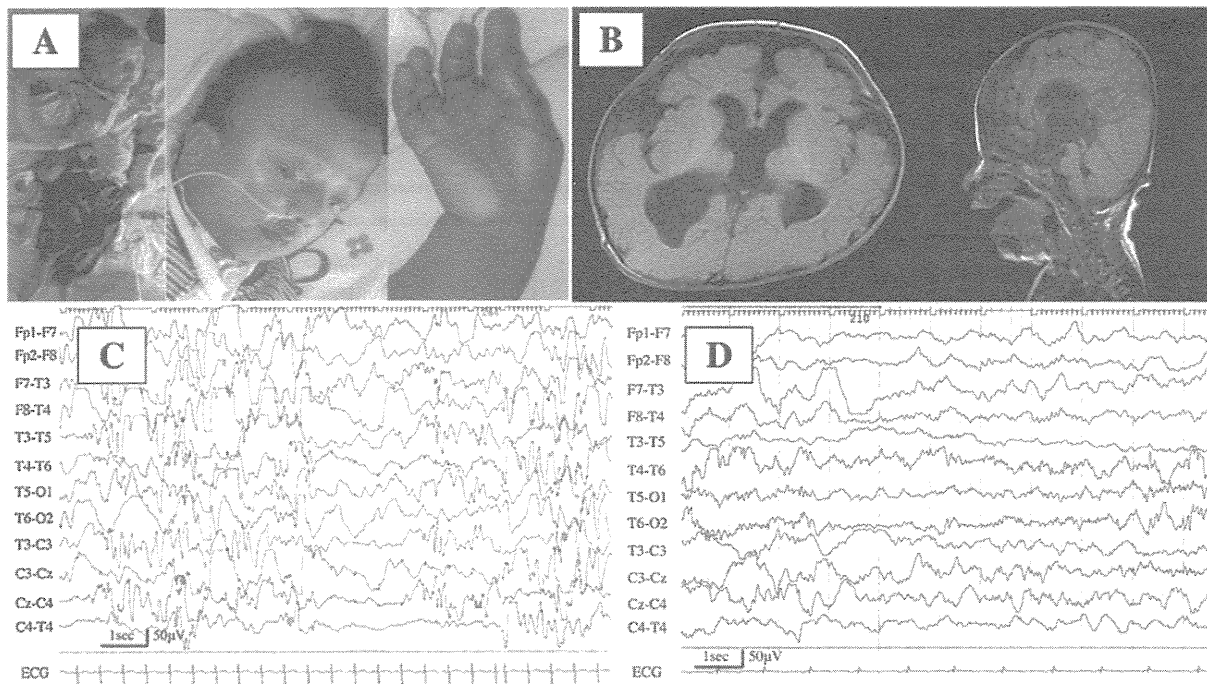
Case 1. “Coarse face,” curly hair, prominent forehead, dysmorphic ears, abnormal loose and pigmented skin, webbed neck, chest deformity, and micromelic dwarfism at six years (A), agenesis of the corpus callosum, ventricular dilatation, diffuse cortical atrophy and severely delayed myelination on MRI images at three years (B), hypsarrhythmia at 11 months (C), asynchronous, high-voltage slow waves with irregular spike-wave or polyspikes with/without waves dominantly in the right temporal-occipital region at six years of age (D) on EEG.
